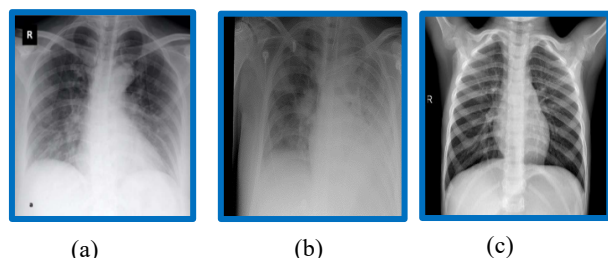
Examples of X-rays images include those for (a) COVID-19 (b) pneumonia, and (c) normal.
